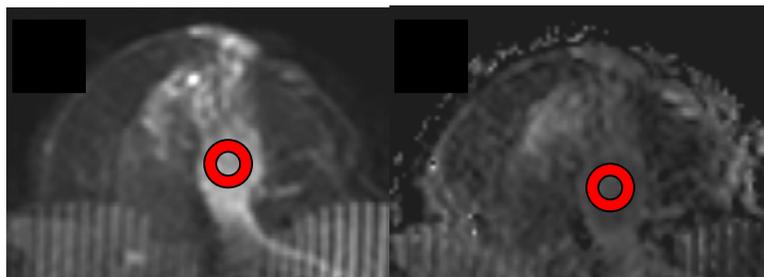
Transaxial DWI b=0 image (A) and ADC map (B) with Region Of Interest (ROI) drawn in the tumor area anterior to obvious artifacts.
